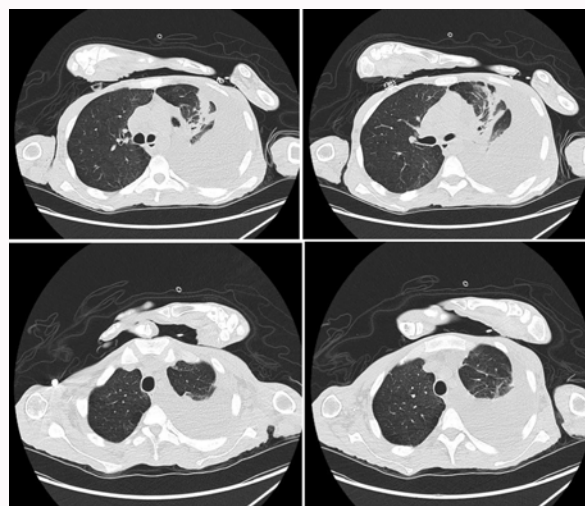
CT Chest showing partial resolution of Bordetella Pertussis empyema of the left lung after starting therapy.
